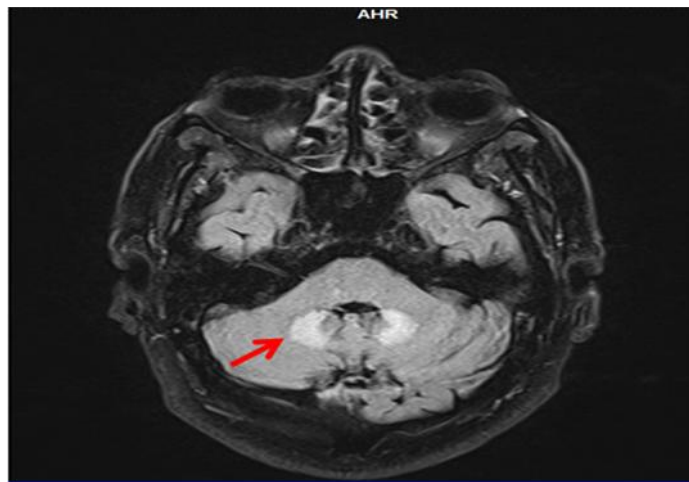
Axial T2 FLAIR image revealed symmetric increased signal intensity in bilateral dentate nuclei (red arrow)
